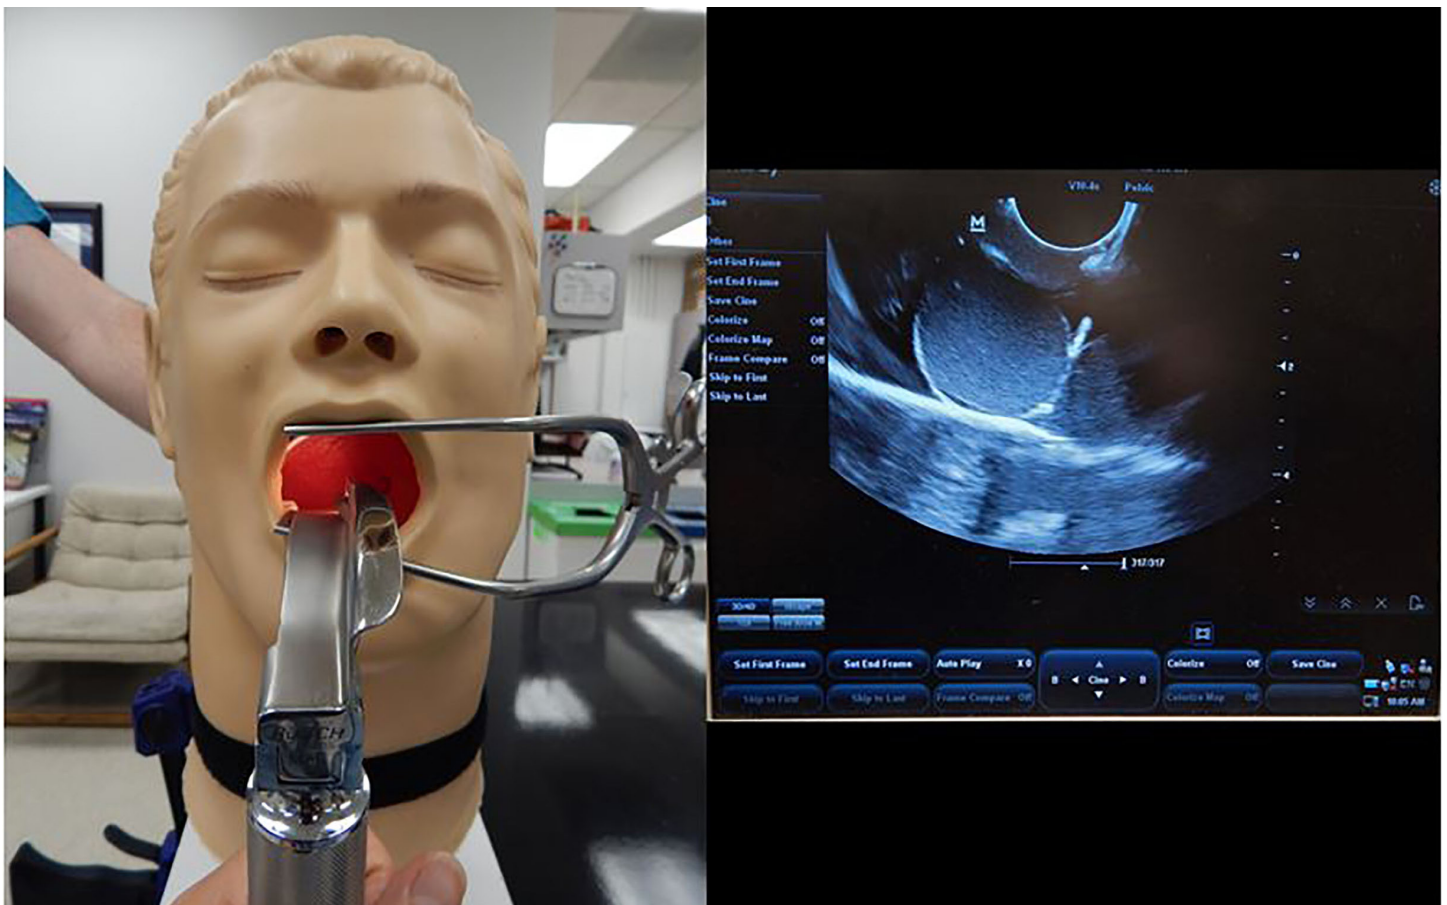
Completed ultrasound-guided peritonsillar abscess task trainer and corresponding ultrasound image.
